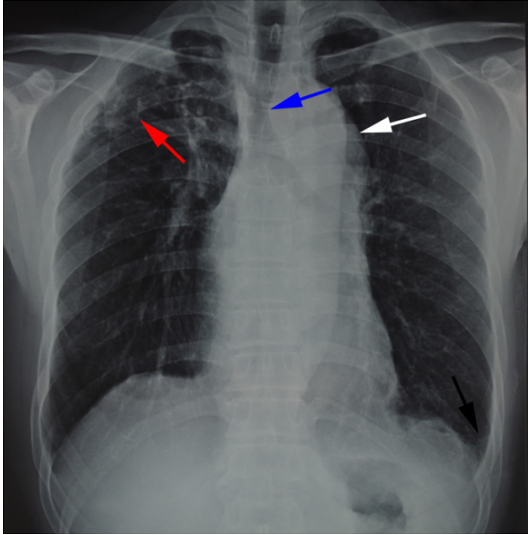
Chest radiography of the patient. Chest radiography revealed stripes and patchy shadows in the right-sided upper lung field (red arrow), left-sided costophrenic angle blunting (black arrow), and broadening of the left upper mediastinum (white arrow), resulting in contralateral shift and stricture of the trachea (blue arrow).
